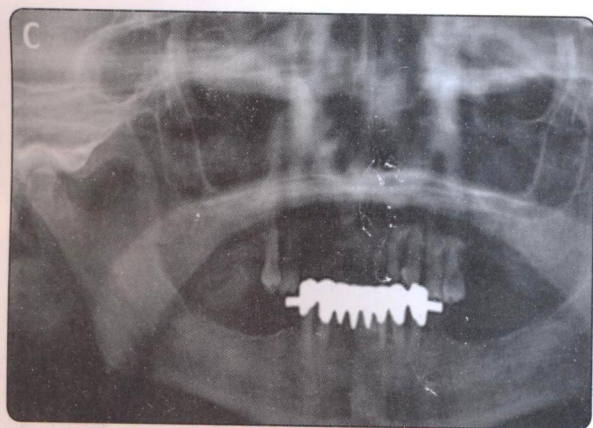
(A) Intra oral preoperative frontal view of the patient mouth with removable partial denture. (B) Intraoral preoperative frontal view of the patient mouth without removable partial denture. (C) Preoperative panoramic radiograph showing remaining upper teeth and lower fixed partial denture.
